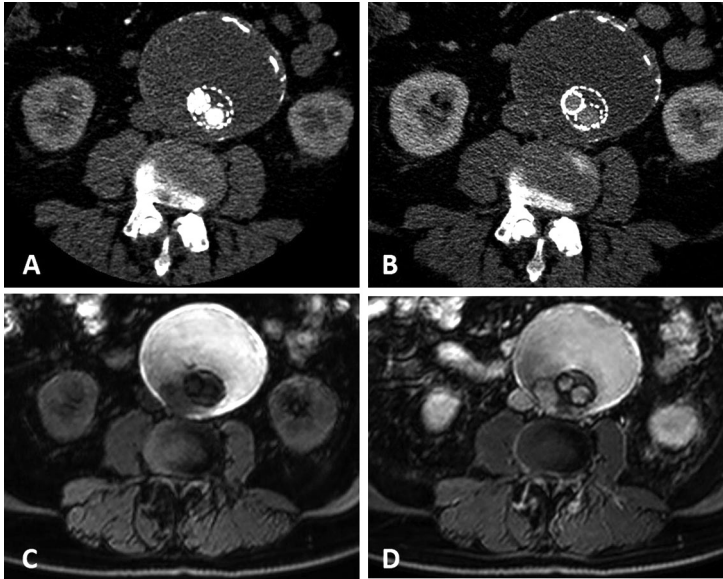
A patient post-EVAR with continued aneurysm growth with no endoleak on arterial phase (A) and late phase (B) CTA, and pre-contrast T1 fat suppressed images (C). The post-contrast T1 fat suppressed images (D) clearly demonstrated a type II endoleak originating from a lumbar artery.
